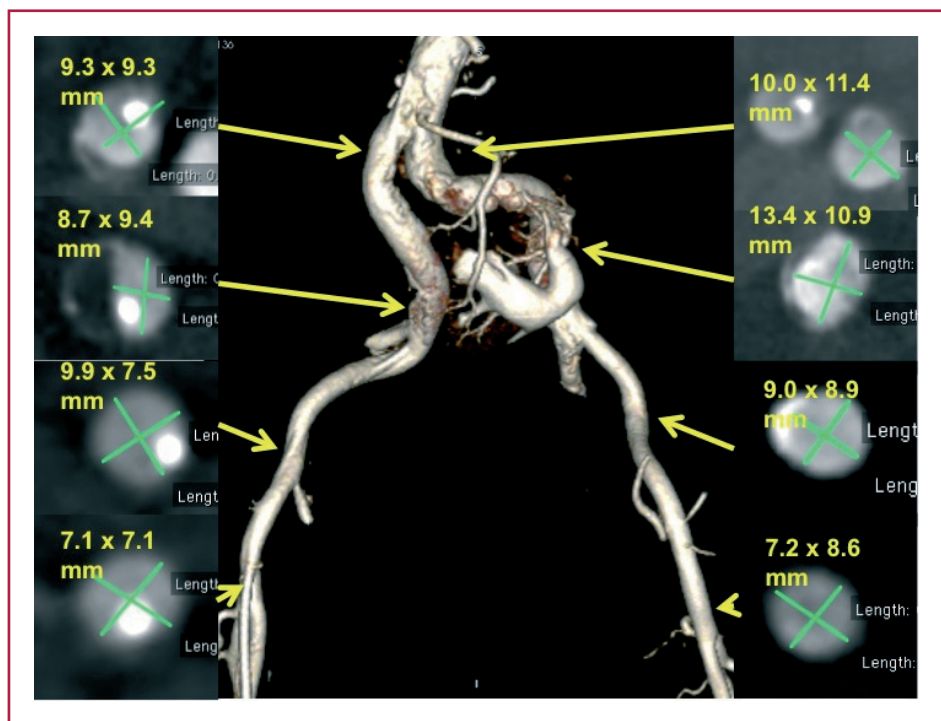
Iliac artery CT angiography obtained with 20 cm³ contrast injection through a pigtail catheter positioned in the infrarenal abdominal artery
